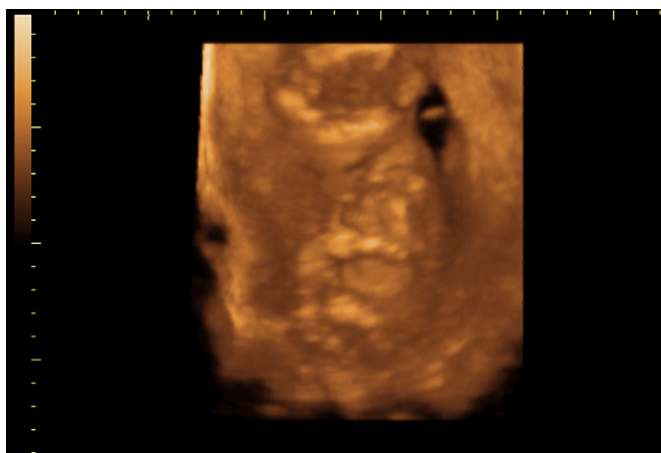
The reconstructed multiplanar three-dimensional ultrasound (3D US) image of fetal osteogenesis imperfecta at 20 weeks' gestation. Short extremities with clearly visible intracranial structures can be clearly noted. 3D US showed a normal contour of the face, especially on the lateral view.
